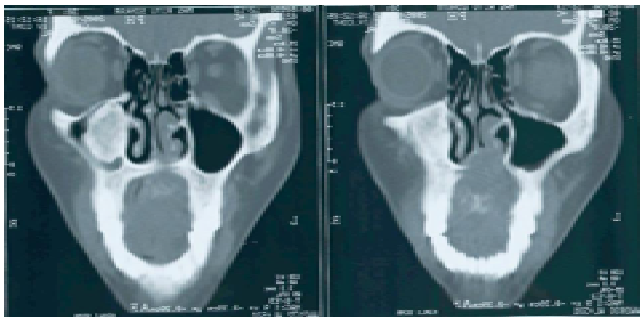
CT scan showing osteoma occupying entire maxillary sinus
